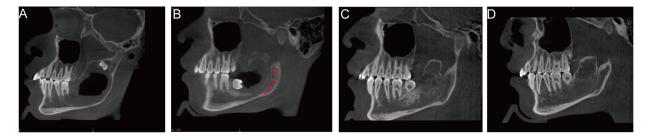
CBCT sagittal view of the left mandible. (A) Sagittal view of CT image at the first visit. (B) Sagittal view of CT image three months after the decompression showing the reappearance of mandibular canal. (C) Sagittal view of CT image ten months after the decompression (before the enucleation). (D) Sagittal view of CT image eighteen months after the enucleation.
